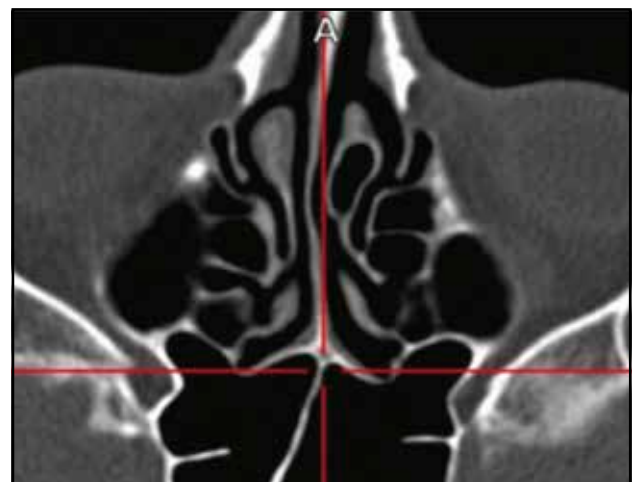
Antero-lateral extension of the sphenoid (crano-facial CT scan, axial slice).
